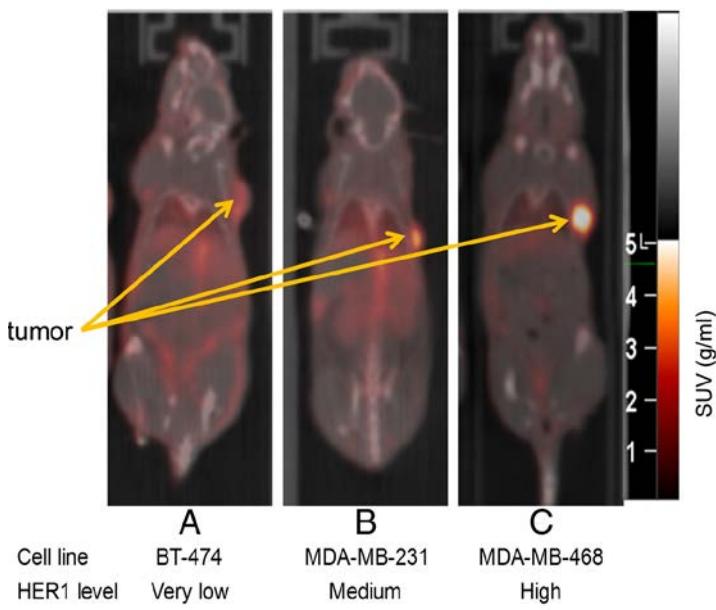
Tumor uptake of ^{89}Zr -panitumumab in sc xenograft models with different levels of EGFR expression. 10.18 ± 1.24 MBq of ^{89}Zr -panitumumab were administered IV via tail-vein, and a 5 min CT scan followed by a 30min static PET scan were performed 96-h post-injection [40].
